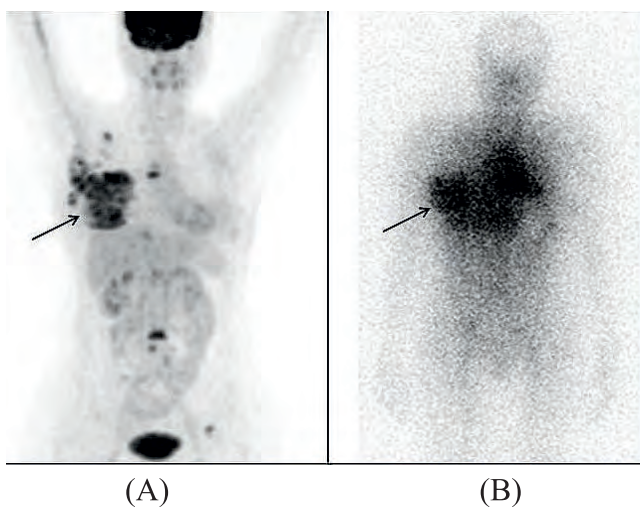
Whole-body scans of a female patient, suffering from metastatic breast cancer, obtained using ^{18}F FDG (A) and ^{177}Lu -Trastuzumab (B), respectively
